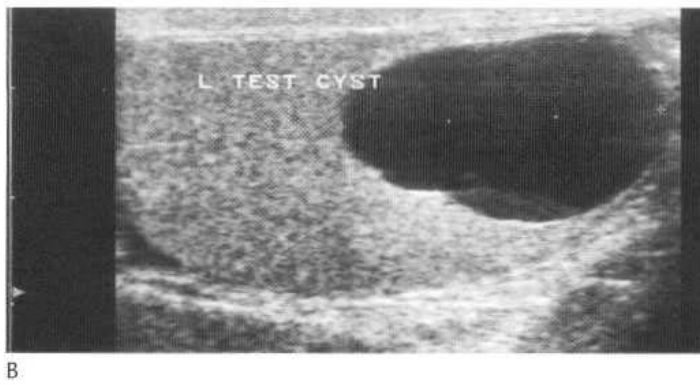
Ultrasound of a small (A) and a large (B) testicular cyst, both showing an echo-free area without any significant solid elements.
